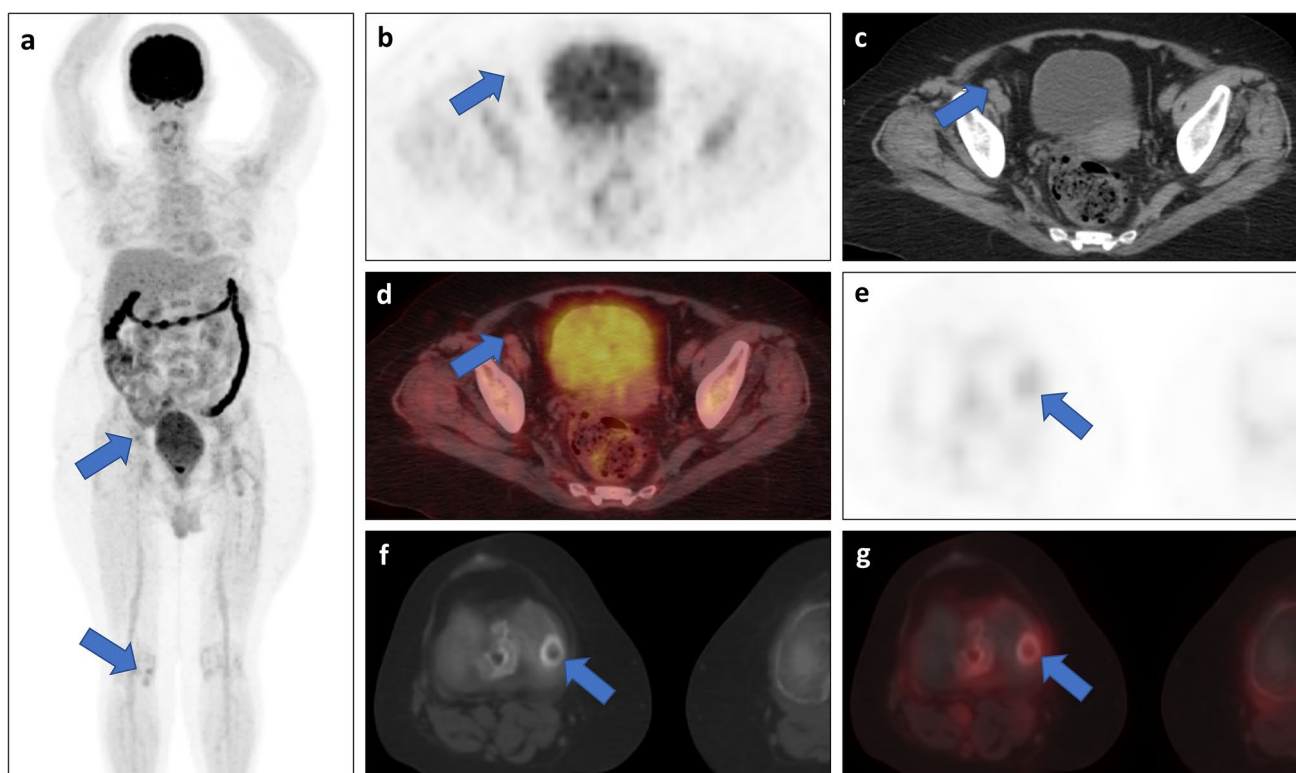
Whole body F-18 FDG PET-CT demonstrating insignificant F-18 FDG uptake when correlated with exact locations on Ga-68 DOTATATE PET-CT images (see Fig. 1). MIP images (a, b, e), followed by corresponding non-contrast-enhanced fused PET/CT
